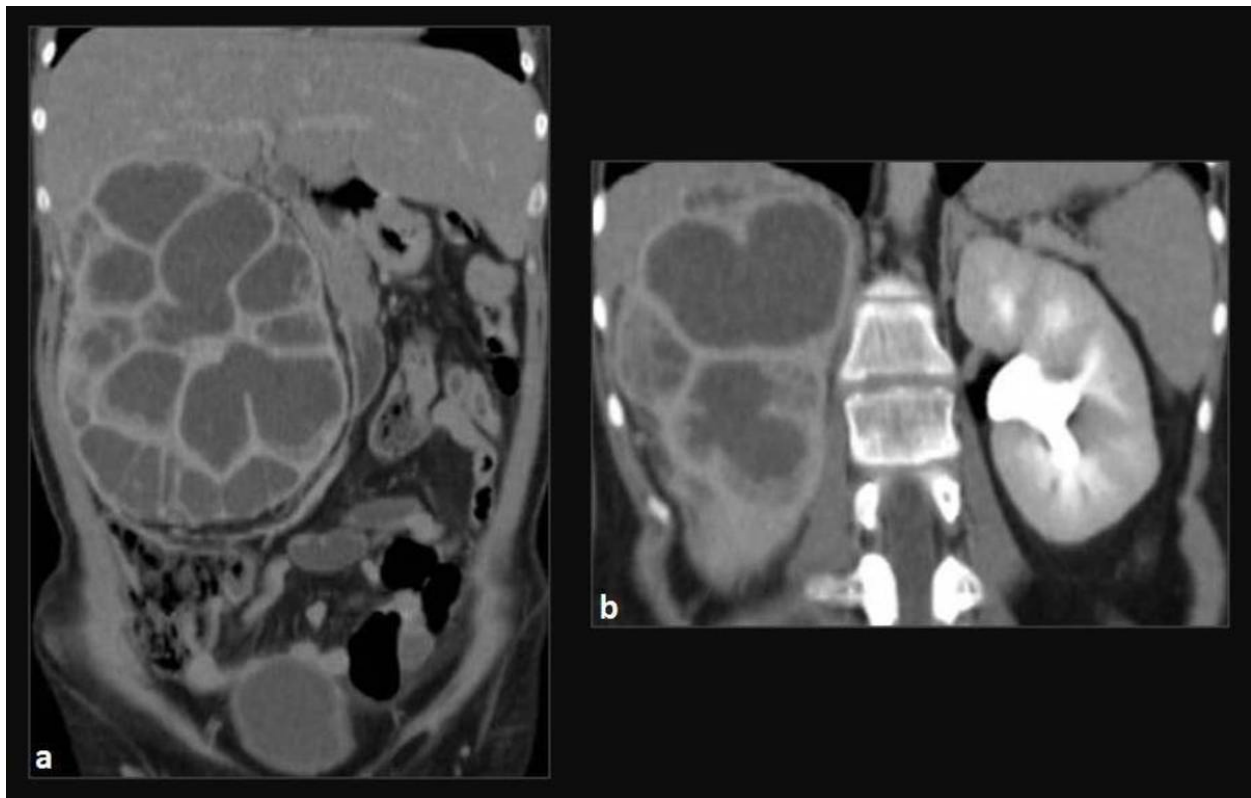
Xanthogranulomatous pyelonephritis (same case as in figs. 20 and 21). Coronal contrast-enhanced CT images (excretory phase) demonstrate an enlarged right kidney with multiple oval hypodense collections replacing renal parenchyma. Renal function is not seen in the affected side.
